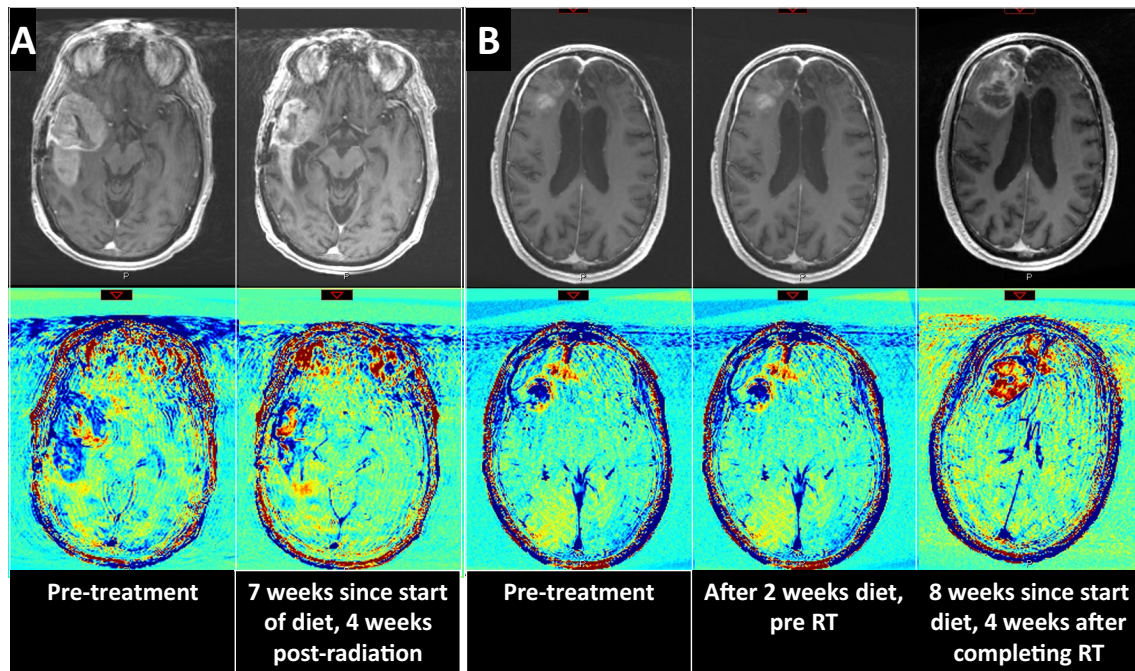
Representative imaging of participants. Upper row - Fast spoiled gradient-echo (FSPGR) Gadolinium-enhanced Magnetic Resonance Imaging (MRI), lower row - Treatment response assessment maps (TRAMs) based upon the difference between early and late enhancement. a Patient #1 Recurrent glioblastoma, post treatment
